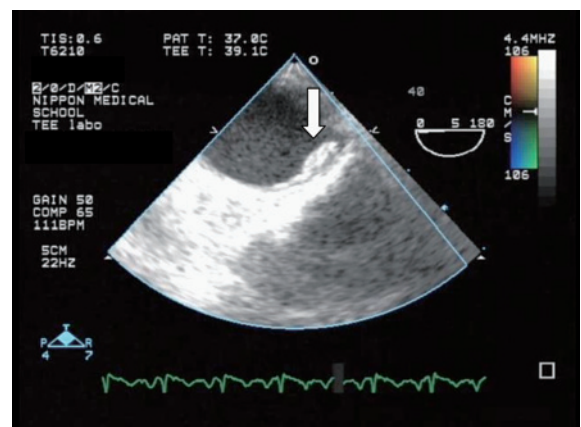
Transesophageal echocardiograph of the patient
